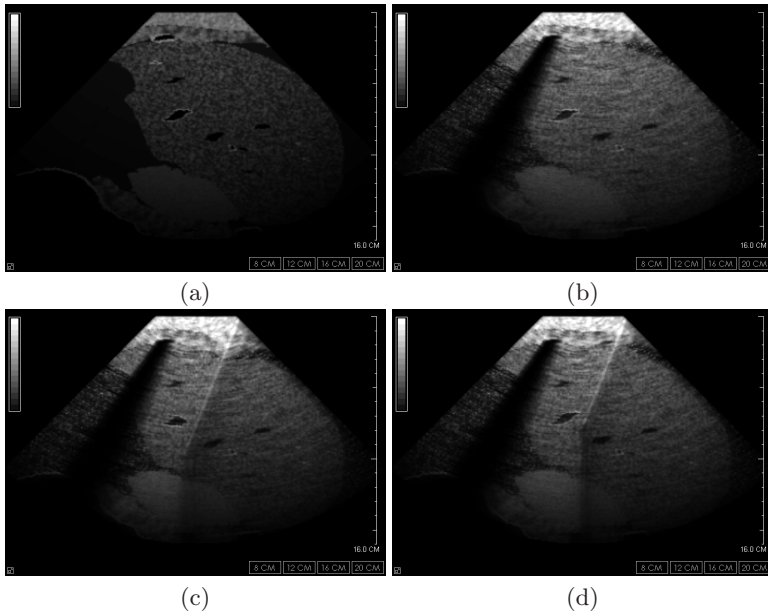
Examples of synthetic ultrasound images. These images are slightly brightened for better display.
